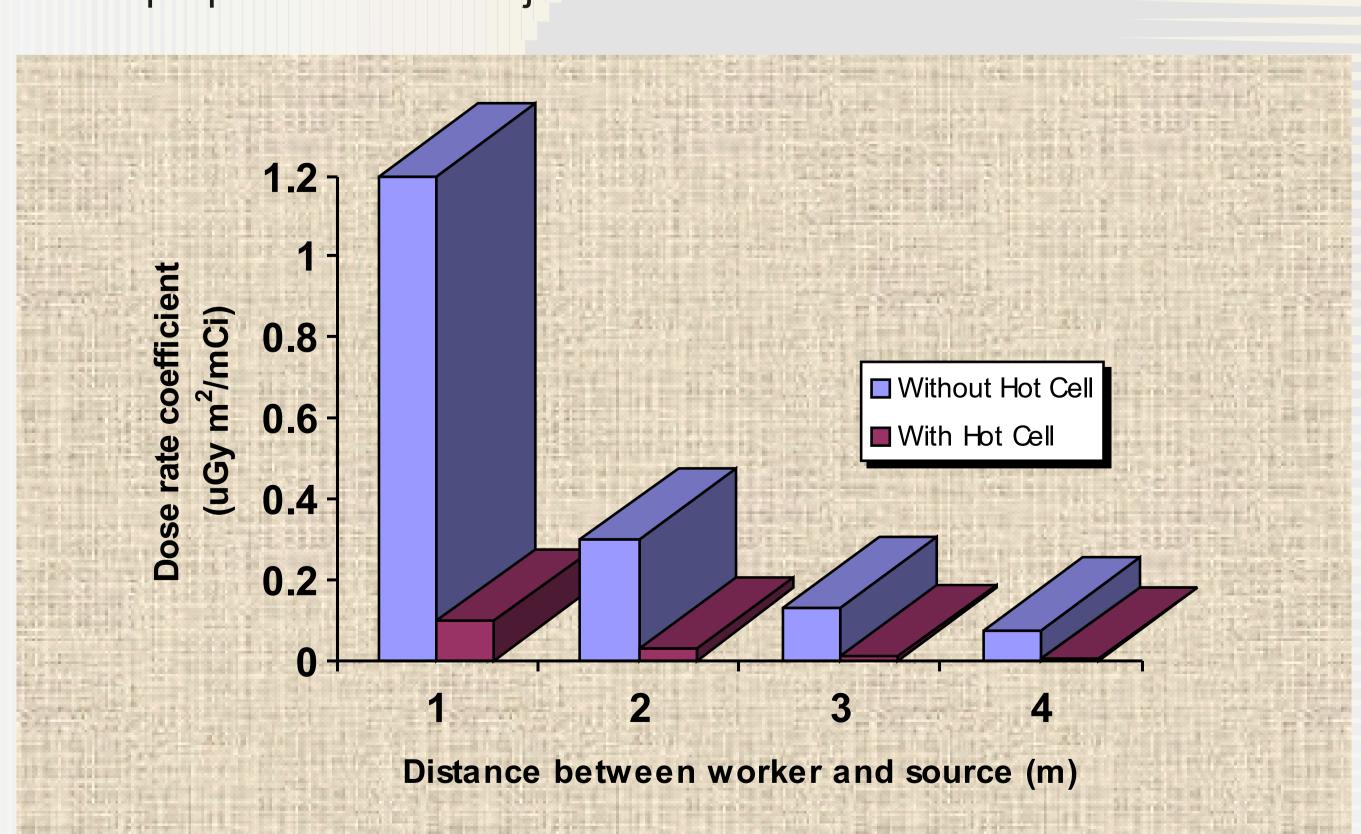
The decrease of the handling time of the FDG source using the Hot Cell to a decrease of the in-taken radiation dose by the operator
